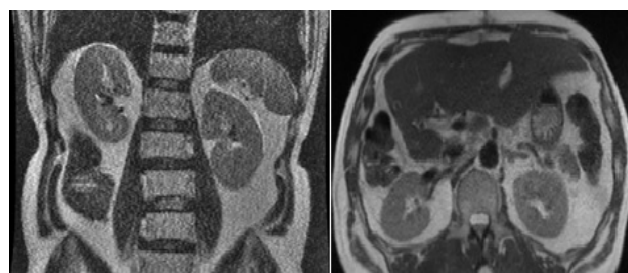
Magnetic Resonance Imaging (MRI) of our patient's kidneys. There is no identifiable mass within the renal parenchyma or surrounding tissue.
